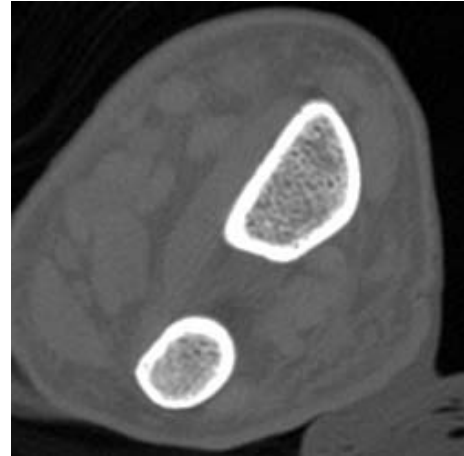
CT image slice from forearm scan.
